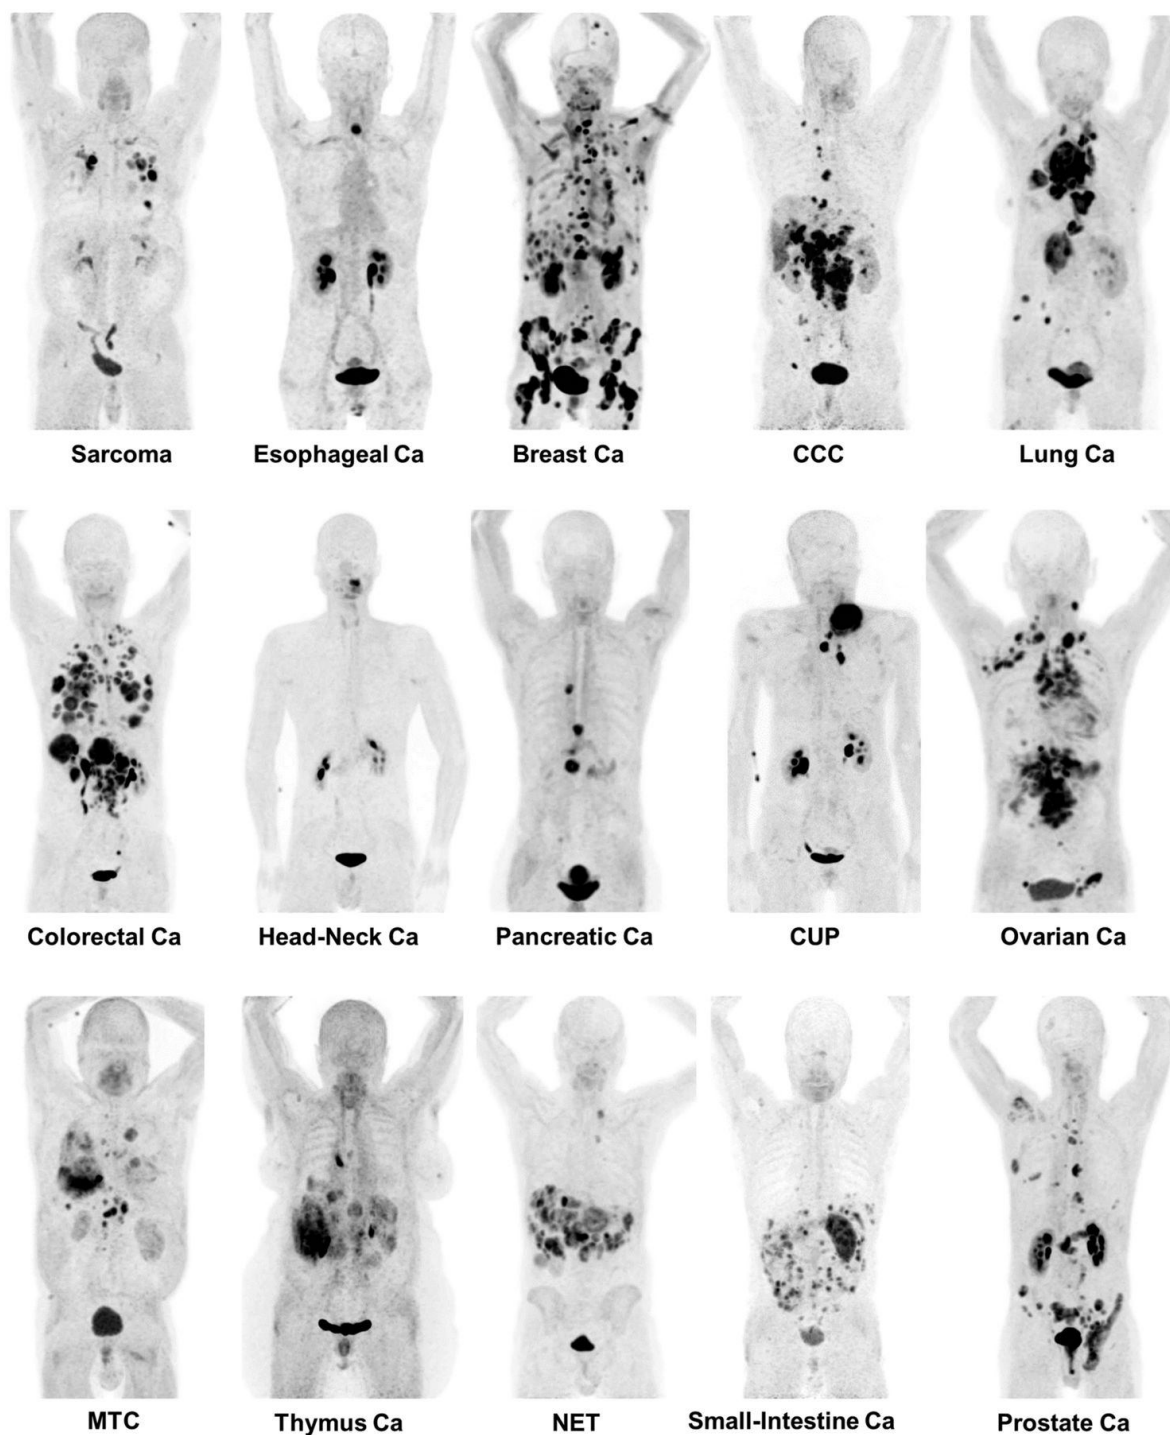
Maximum-intensity projections of $[^{68}\text{Ga}]\text{FAPI}$ PET/CT in 15 patients with distinct confirmed tumor entities. From “ $[^{68}\text{Ga}]\text{FAPI}$ PET/CT: Tracer uptake in 28 different kinds of cancer” by Clemens Kratochwil, Paul Flechsig, et al. 2019. Page 803. Copyright by Journal of Nuclear Medicine. Note: Medullary thyroid cancer (MTC), cholangiocellular carcinoma (CCC), neuroendocrine tumour (NET), carcinoma of unknown source (CUP), and cancer (Ca).
